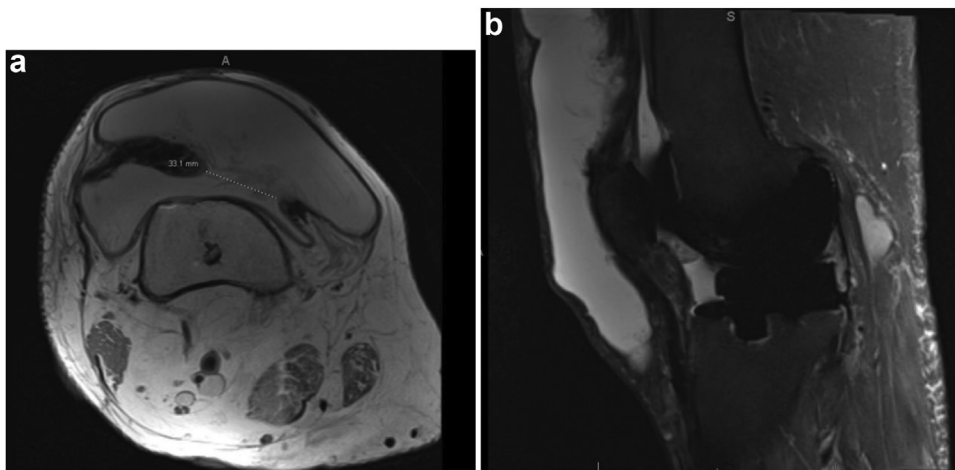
(a) Axial and (b) sagittal MRI images show a large knee joint effusion with communication to a large subcutaneous fluid collection overlying the right knee and extending superiorly through a large defect in the quadriceps repair. MRI, magnetic resonance imaging.
